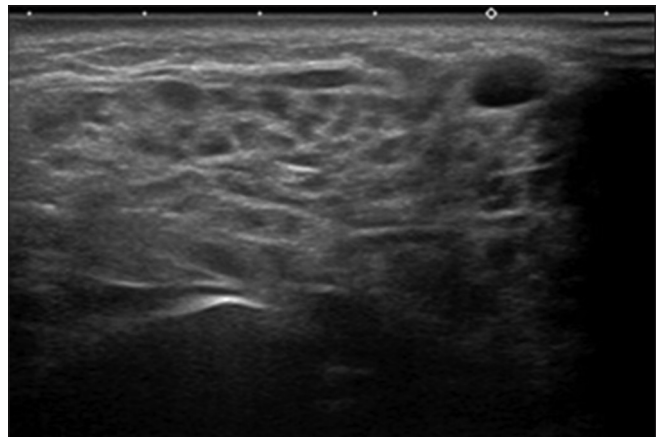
Sonogram of the right parotid gland shows heterogeneous echotexture with small and indistinct hypoechoic nodules. Similar findings are found over the left parotid and bilateral submandibular glands
